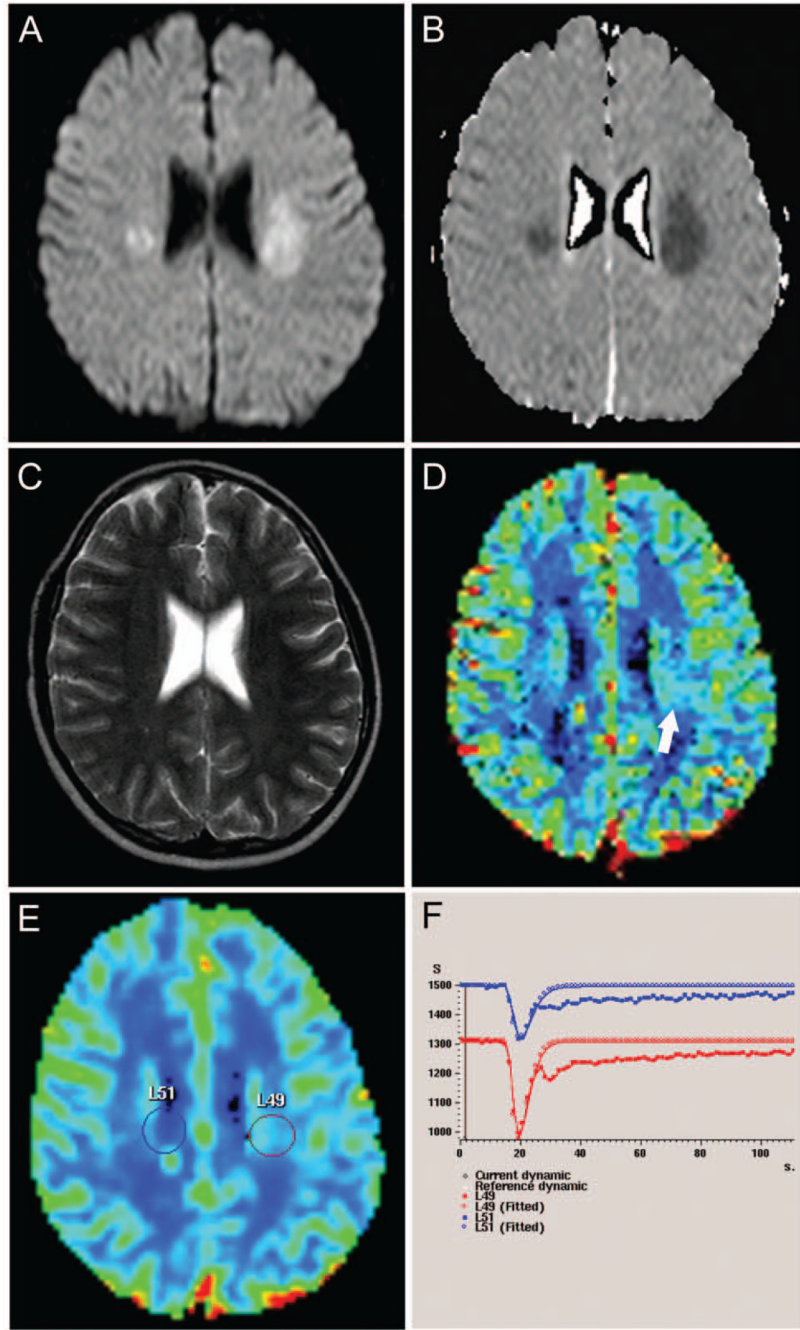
Axial diffusion-weighted image (A) and apparent diffusion coefficient map (B) show round foci of diffusion restriction in the corona radiata bilaterally. There is no visible abnormality on the T2-weighted image (C). Magnetic resonance perfusion index map (D) shows focal increased cerebral blood flow in the left-side lesion (arrow). No perfusion change was noted in the right-side lesion. The left-side centrum semiovale, marked by the circle as the lesion of interest (E), is depicted graphically by the red curve of the negative enhancement integral (F). The depth of the peak representing the left-side lesion (red curve, F) is significantly greater than the peak of the right-side area (blue curve, F), indicating an increase in cerebral blood volume and perfusion in the left-side lesion.
